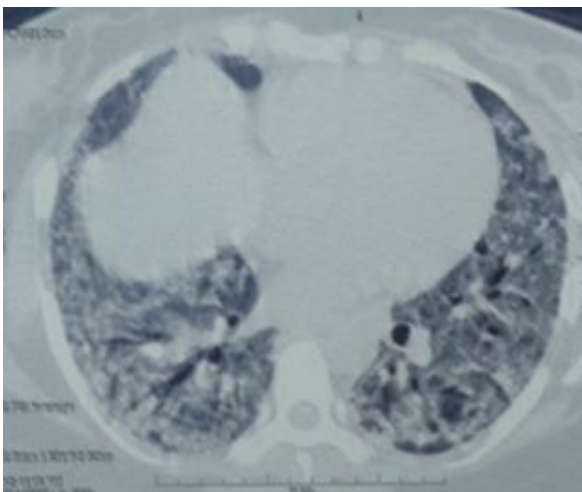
Figure (G)–Initial HRCT showing bilateral diffuse multizonal thick ground glass opacity with bronchiectasis changes.
